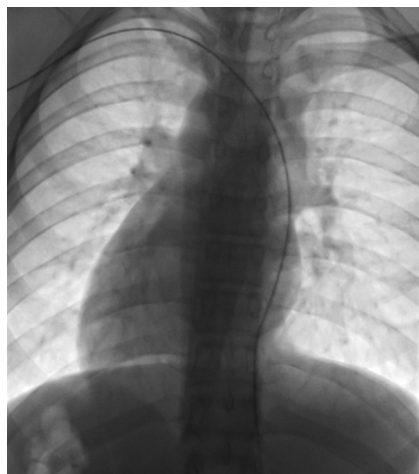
Chest radiograph during the embolization procedure from the right brachial access vein showing dextrocardia and a catheter traversing the left-sided superior vena cava
